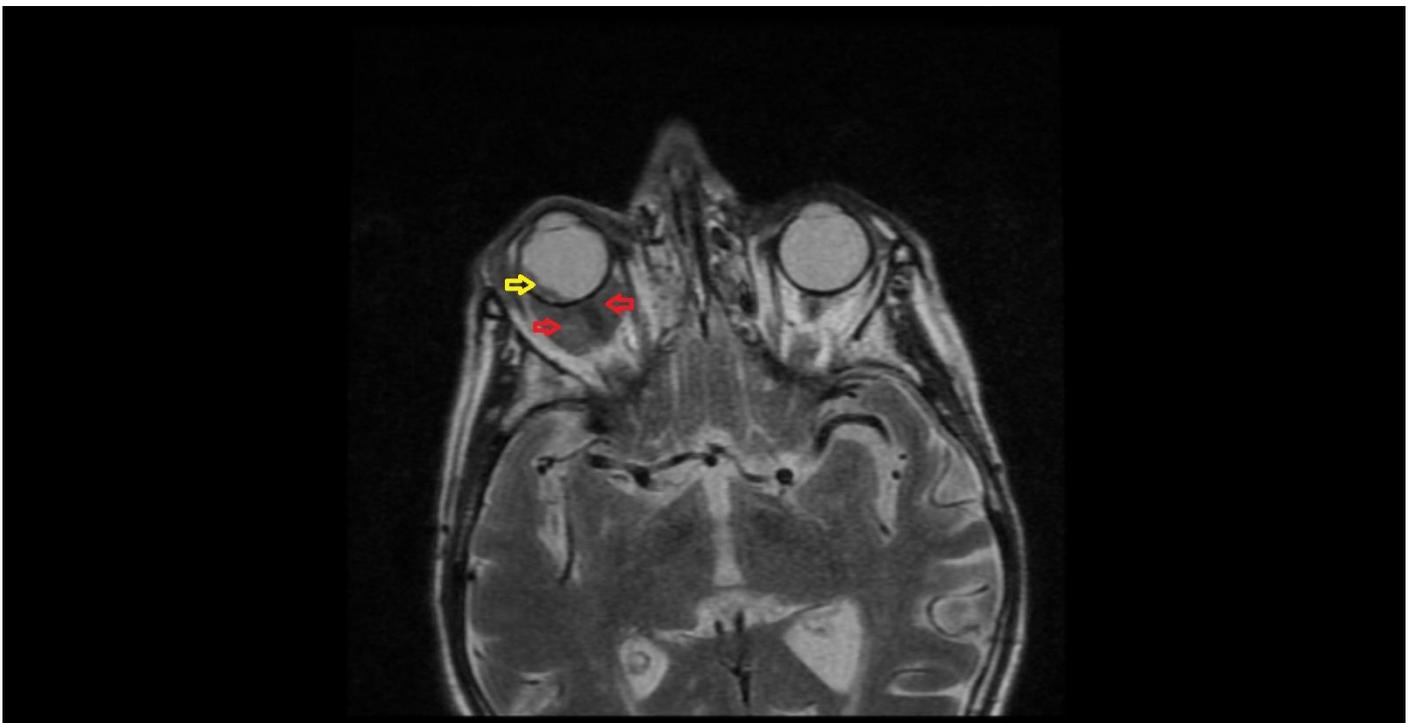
The axial T2 MRI scan of optic nerve sheath meningioma (red arrow) and globe invasion (yellow arrow)
